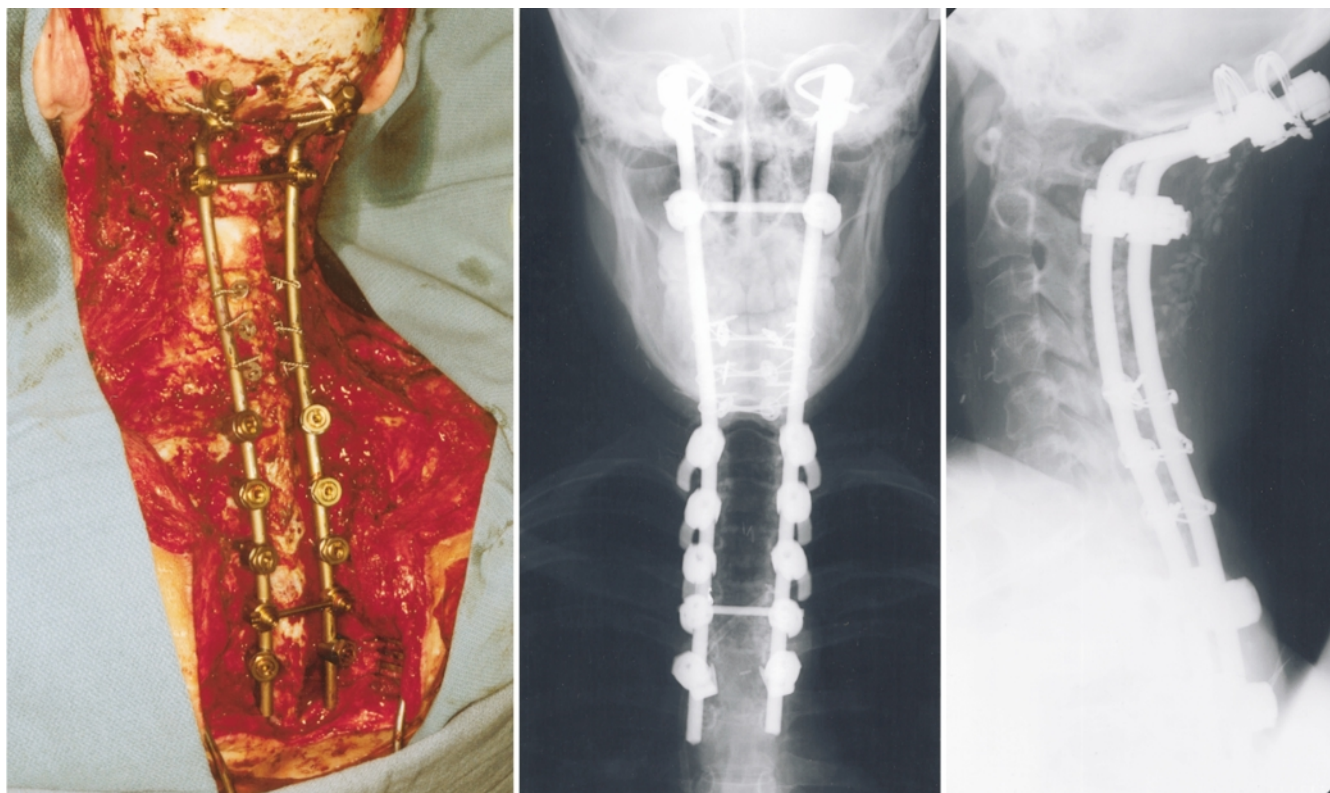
Case 12. *Left*: Intraoperative photograph demonstrating resection of sarcoma and OCT fixation. *Center* and *Right*: Anteroposterior and lateral radiographs obtained postoperatively.
